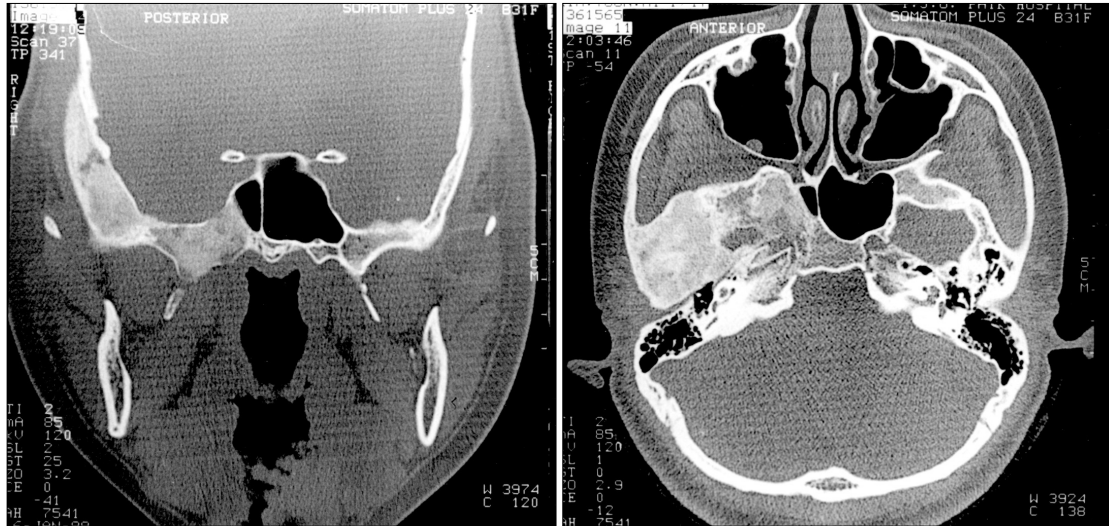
Temporal bone CT scan showed a fibrous dysplasia involving temporal bone and sphenoid sinus (ground-grass appearance).
